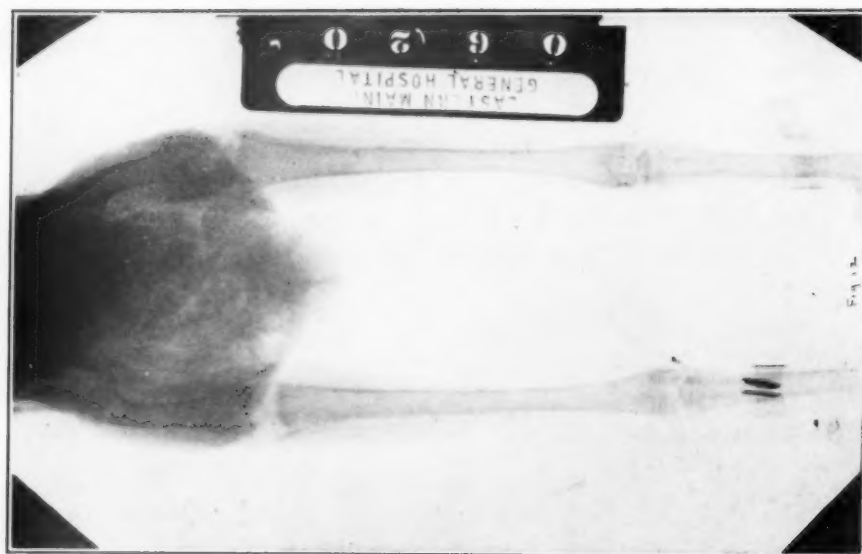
A roentgenograph of the larger chicken in Fig. 2.
